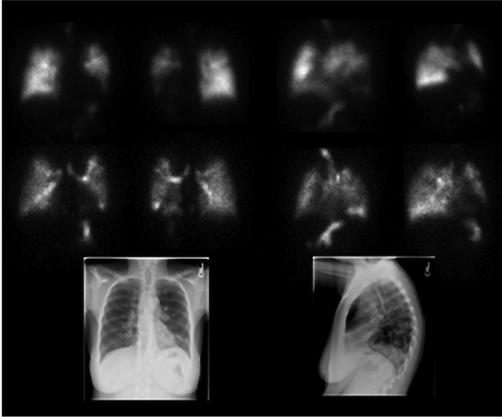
A 54-year-old woman with sarcoidosis with normal chest X-ray and LLL-matched perfusion defects concerning with high probability pulmonary emboli (PE) in left lower lobe.
